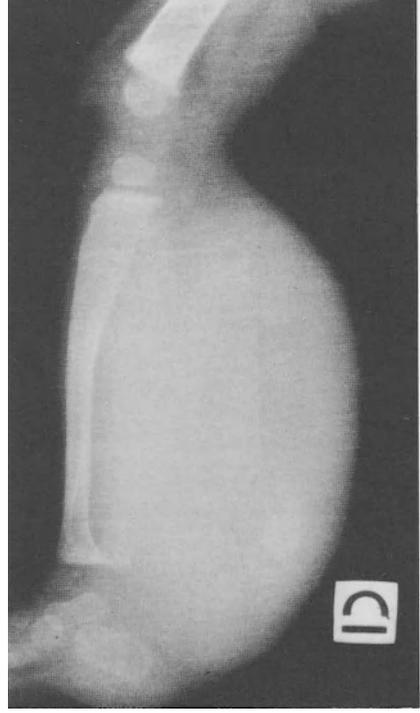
Radiograph of the limb shown in Fig. 22
